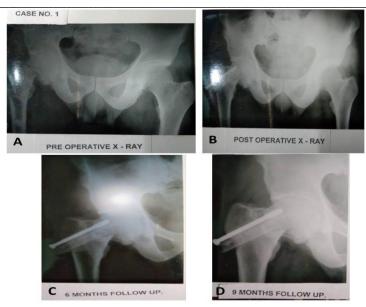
Case showing; A) Pre-operative X-ray, B) Post-operative X-ray; C) 6 months follow up; D) 9 months follow up
